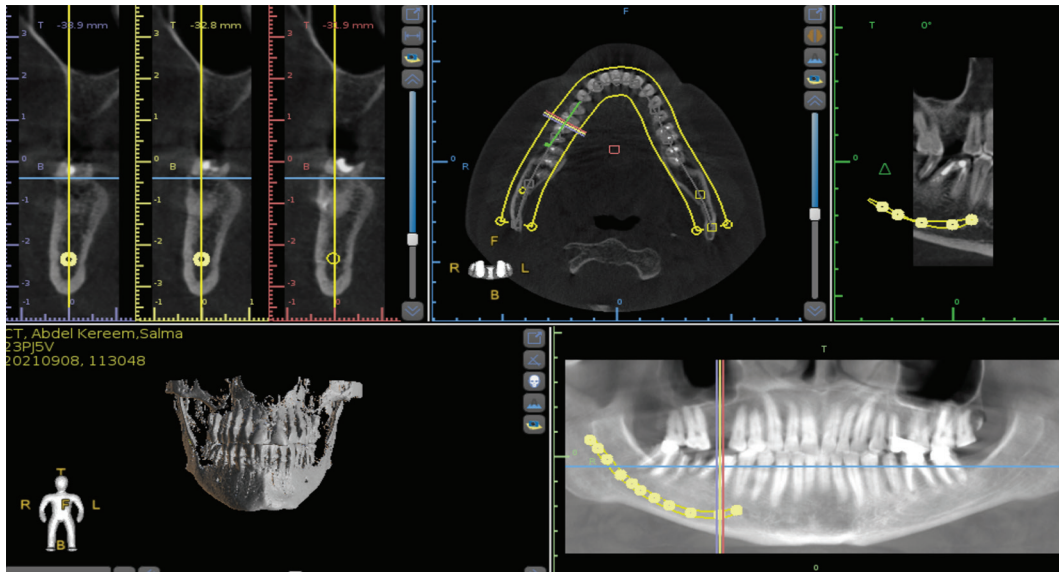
CBCT analysis for proper implant placement using blue sky bio
